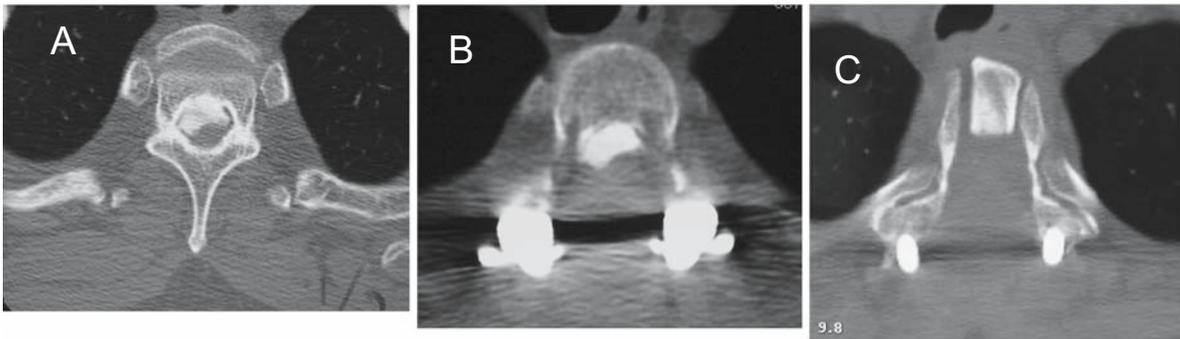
Computed tomography images at the T2 level. A Before operation. B After the step 1 operation. C After the step 2 operation (circumspinal decompression)
